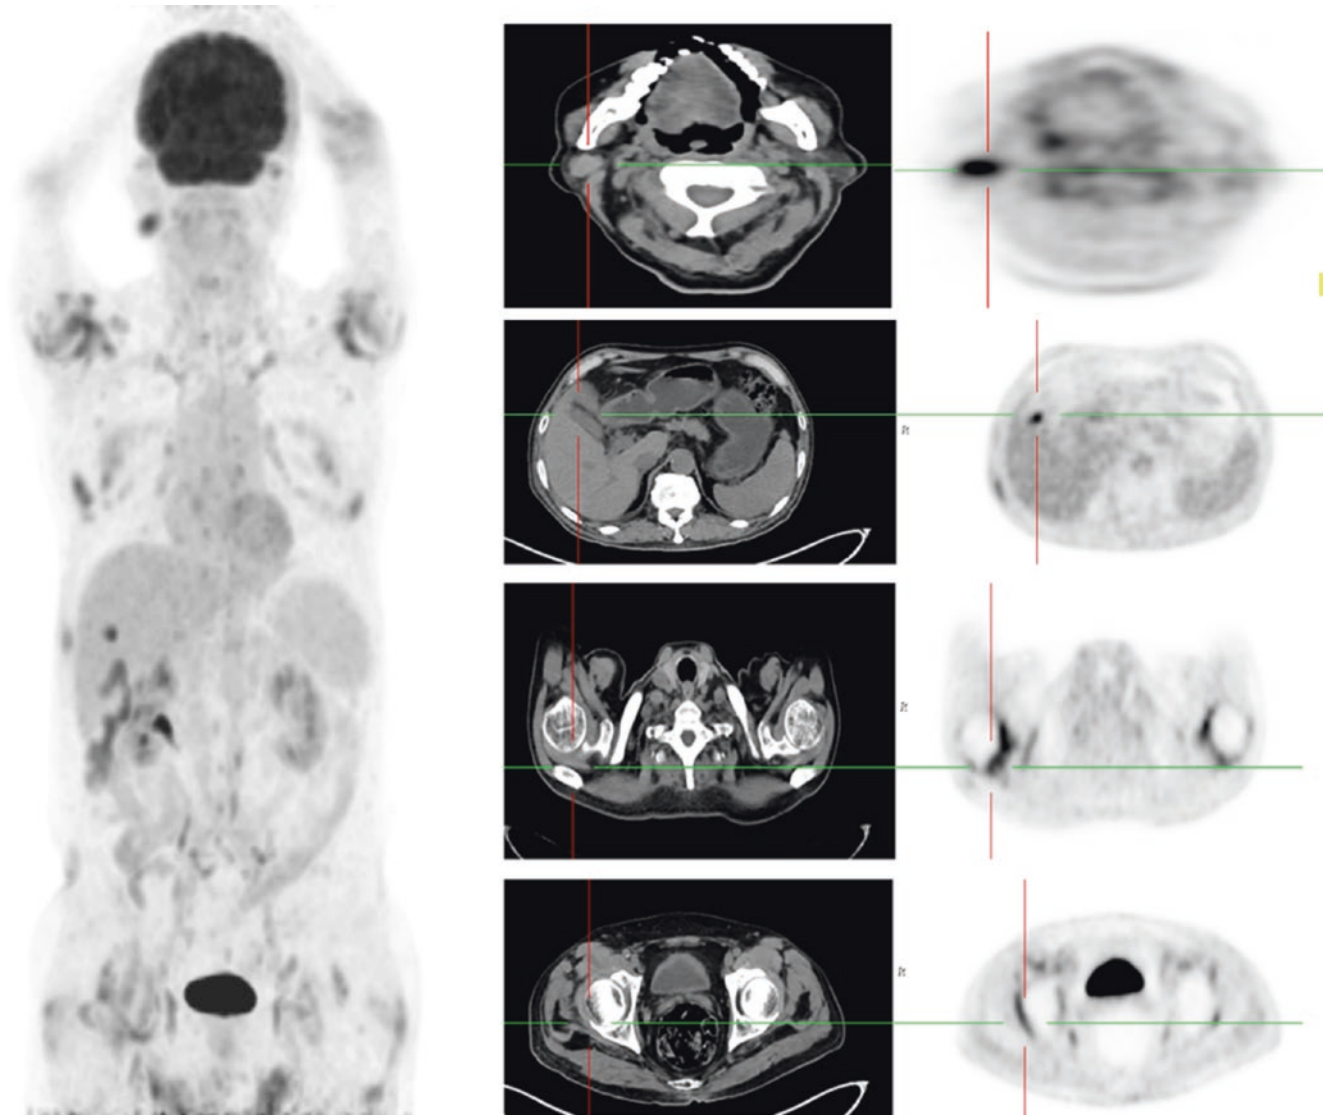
^{18}F -FDG PET/CT image
